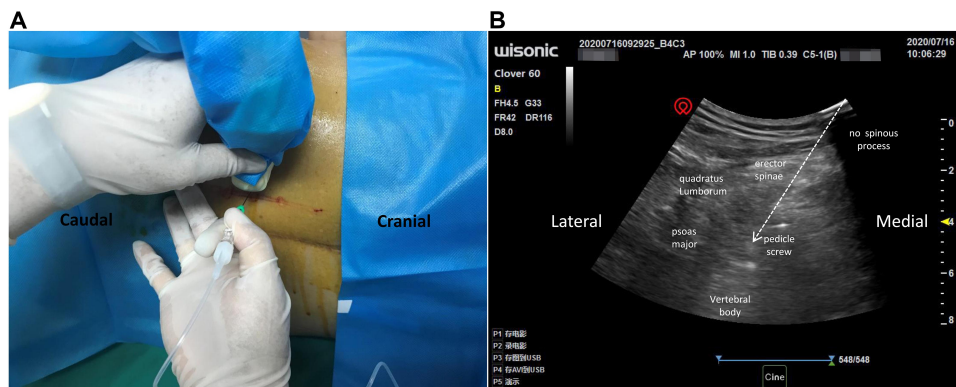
Ultrasound and patient set-up for L4 PVB. (A) Performance of the L4 PVB using paramedian transverse oblique scanning with needle in-plane approach. (B) Sonoanatomy of L4 PVB. The vertebral body, pedicle screw, erector spinae, psoas major, and quadratus lumborum were visible. The white arrow indicates the needle path.
